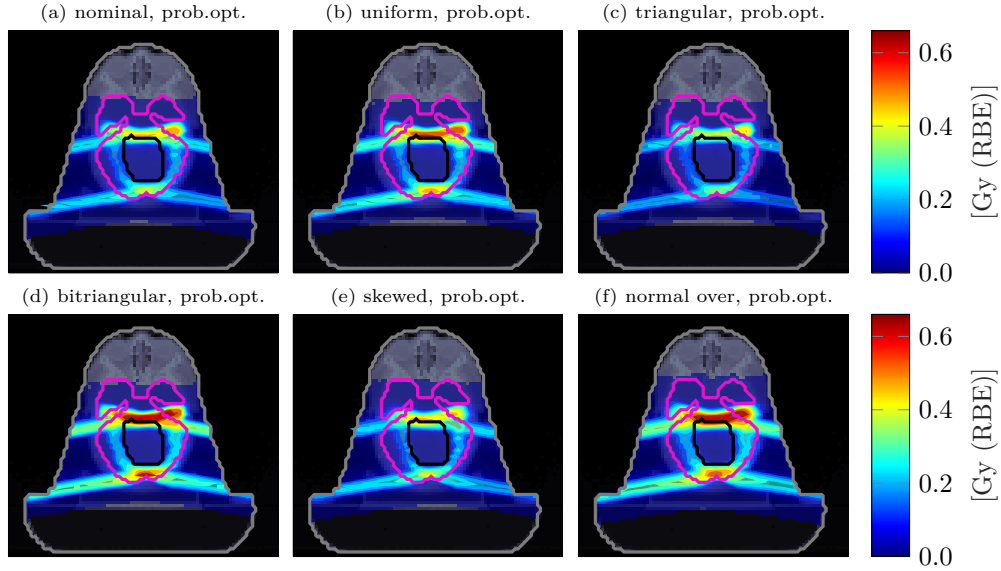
Uncertainty quantification results for the intra-cranial II case. Transversal CT image is overlaid by transparent dose colorwash representing the standard deviation of the RBE weighted dose assuming different PDFs. Pencil beam intensities are based on probabilistic optimization on the CTV. Two proton beam directions from 100° and 260° were defined. The black contour denotes the CTV whereas the pink contour depicts the brain structure.
